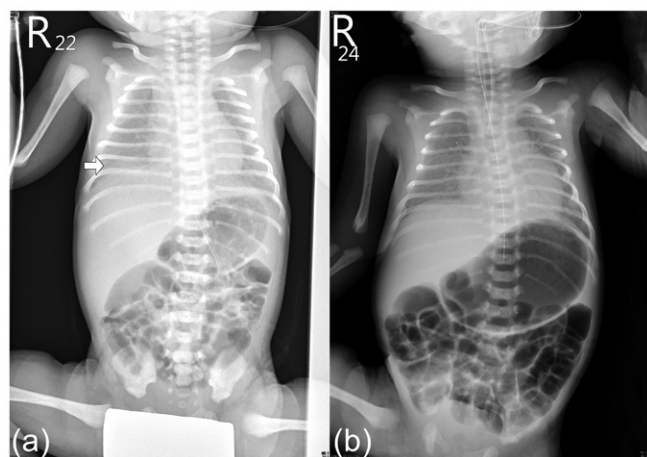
Chest radiographs: A) shows a reticular granular pattern, grade II–III (arrow); B) taken before air transport.
